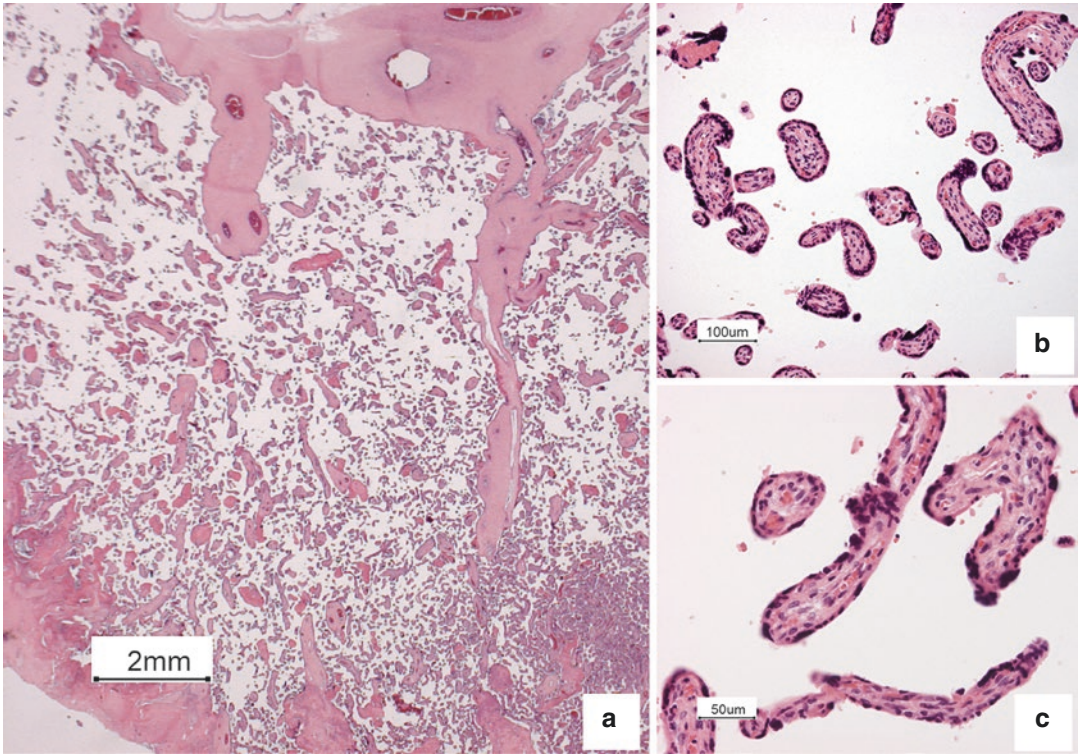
(a) Overview; (b and c) high-power detail of villi with ischaemic changes of trophoblast lining): mother G3P1, ultrasound at 20 weeks showed normal growth and from 28 weeks FGR was demonstrated with an estimated birth weight below third percentile. At 32 weeks GA, an abnormal umbilical artery Doppler was
